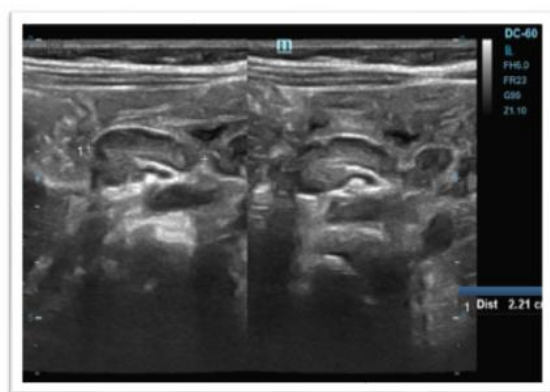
Ultrasound image showing enlarged oval hypoechoic mesenteric lymph nodes in the right lower abdomen. Features are suggestive of reactive mesenteric lymphadenopathy or mesenteric lymphadenitis.
